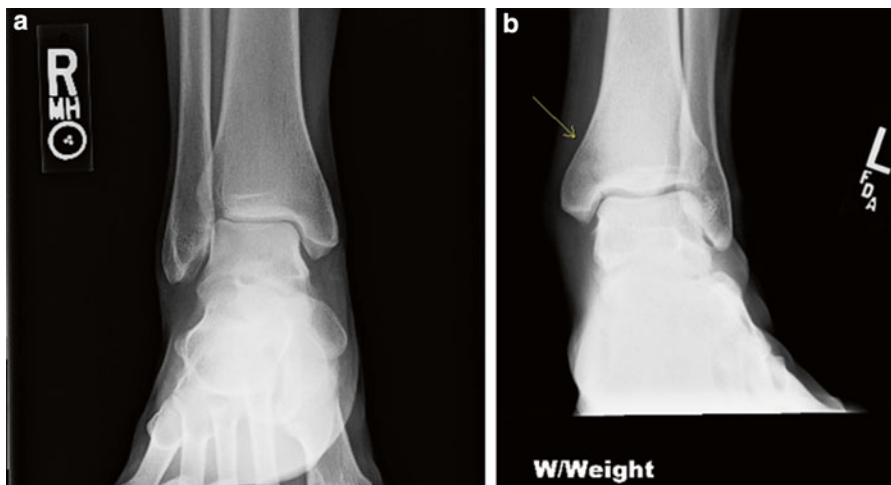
(a) AP ankle radiograph of a 47-year-old active female with 2 weeks of medial ankle pain. These radiographs are normal but the patient went on to be diagnosed
